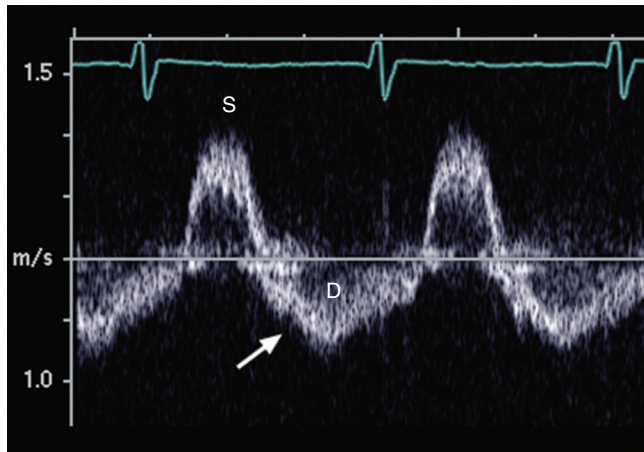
■ Continuous Doppler ultrasound of the abdominal aorta with antegrade aortic flow during systole (S) and holodiastolic flow reversal during diastole (D), consistent with severe aortic regurgitation (arrow).
